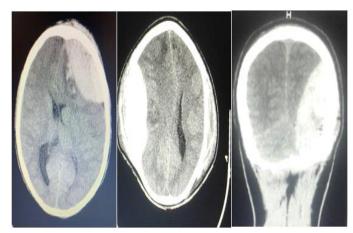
Representatives Pre-operative CT images showing Acute EDH
